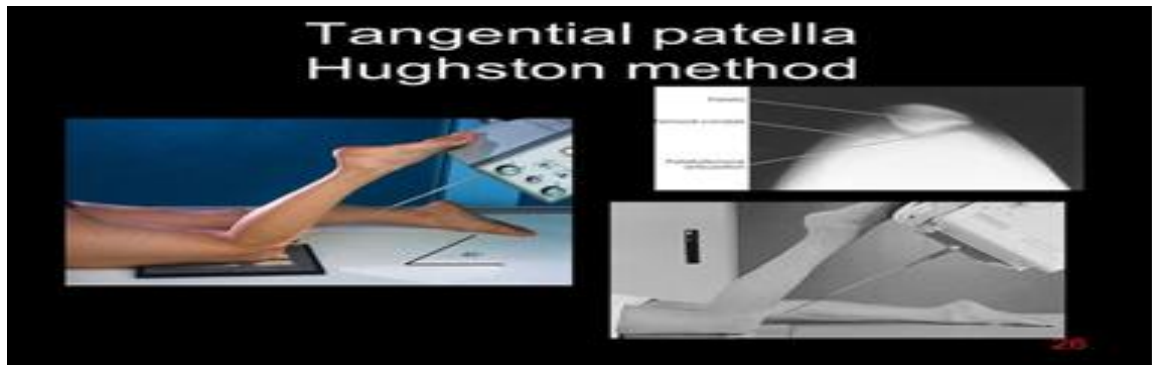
Hughston (Jaroschy) tangential patellar method, showing a prone patient with the knee flexed to approximately 45°, a caudally angled X-ray beam directed tangentially to the patellofemoral joint, and the resulting axial radiograph highlighting patellar alignment and joint congruence.
